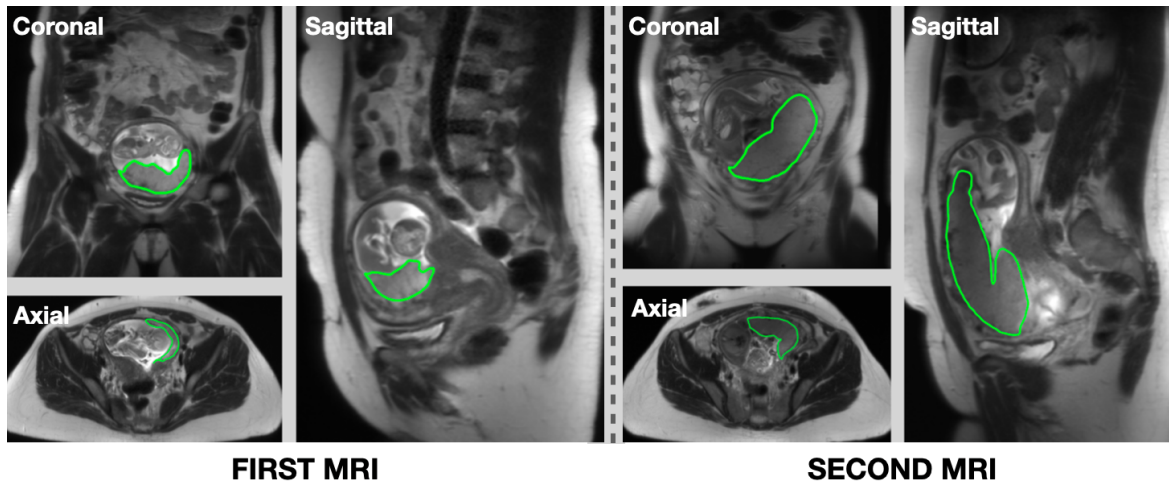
Representative placental MRI images in three imaging planes at the first MRI at 15.3 weeks (left; volume = 119cm^3) and second MRI at 21.3 weeks (right; volume = 270cm^3). The placenta was manually contoured and shown as the green line.
